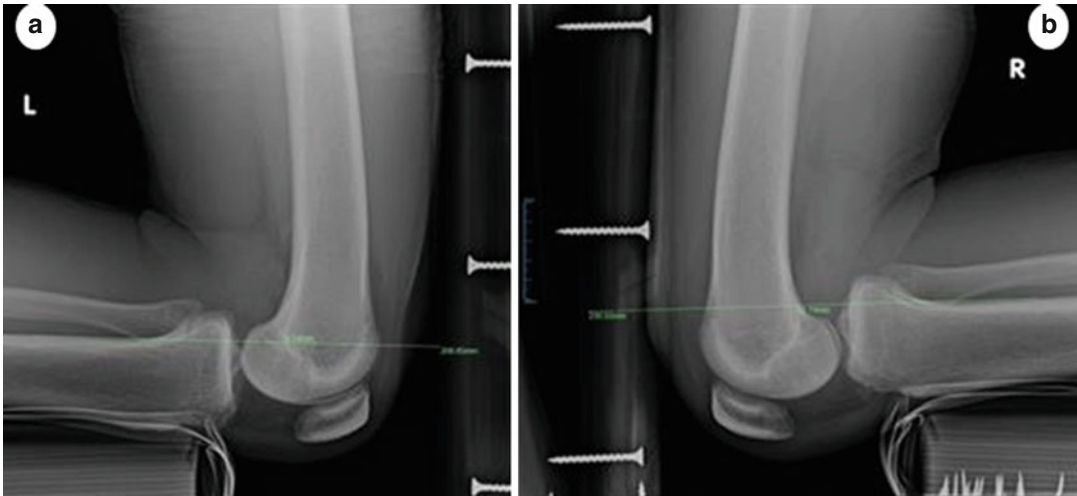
Single-leg kneeling posterior stress radiographs of the same patient demonstrating a substantial side-to-side difference in posterior tibial translation. (a) Posterior stress radiograph of the left leg with no measured posterior translation. (b) Posterior stress radiograph of the right leg with posterior translation measured at
